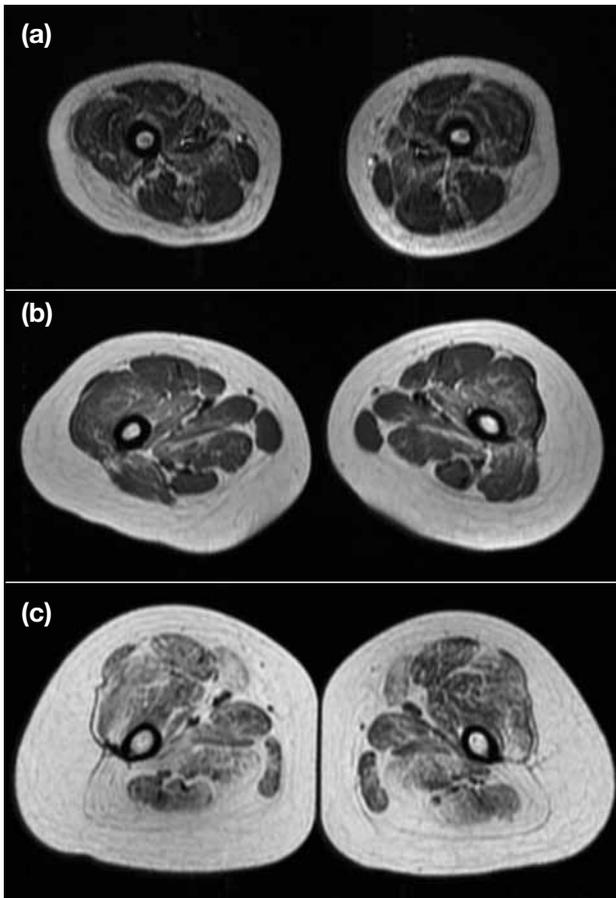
Axial T1-weighted magnetic resonance images of the thigh. (a) Patient 1: there is involvement of vasti and adductor magnus and brevis, with relative sparing of rectus femoris, gracilis, adductor longus, semimembranosus and long head of biceps femoris. (b) Patient 2: moderate fat infiltration at bilateral vastus lateralis, vastus intermedius, vastus medialis and adductor magnus. Mild fat infiltration is also observed at bilateral sartorius and biceps femoris. Bilateral rectus femoris, gracilis, adductor longus and semitendinosus are spared. (c) Patient 3: there is diffuse fat infiltration. Rectus femoris, adductor longus, gracilis and semitendinosus muscles are relatively less severely involved.
